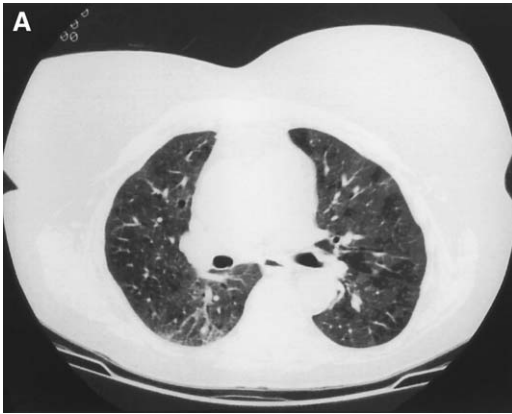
Hypersensitivity lung reaction secondary to methotrexate in two patients. (A) HRCT image of a 42-year-old woman shows patchy areas of ground-glass opacities in both lungs. (B) HRCT image of a 46-year-old man shows ground-glass nodules in the right lung (arrows).
